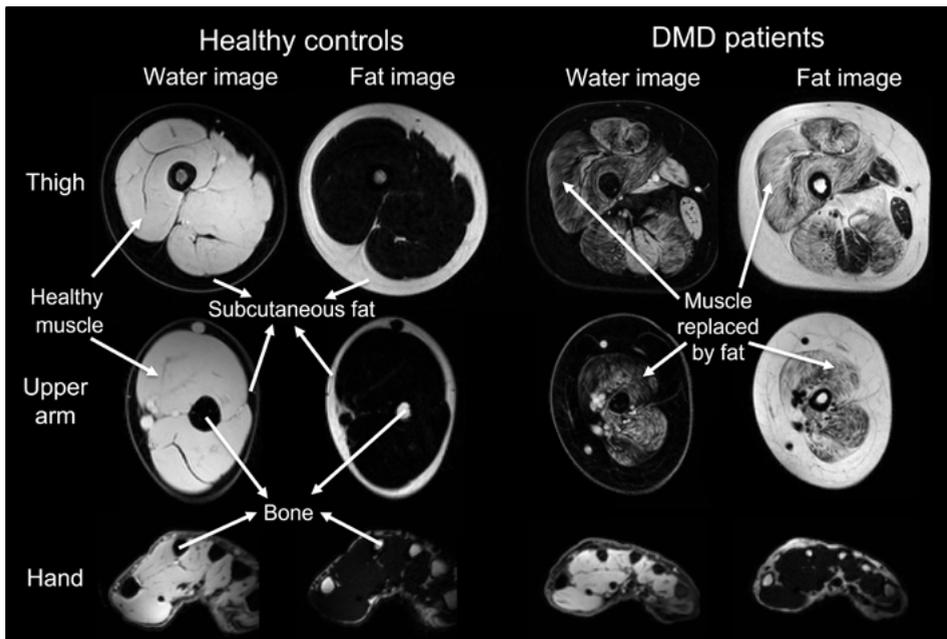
Dixon muscle MRI images of the extremities
